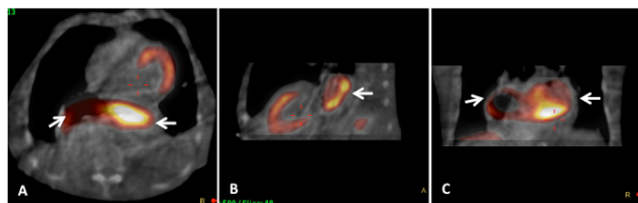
Superimposed SPECT and CT images in the transaxial (A), sagittal (B) and coronal (C) sections, showing a large retro-cardiac mass with radiotracer uptake, extending above the superior extent of the heart (arrows).
